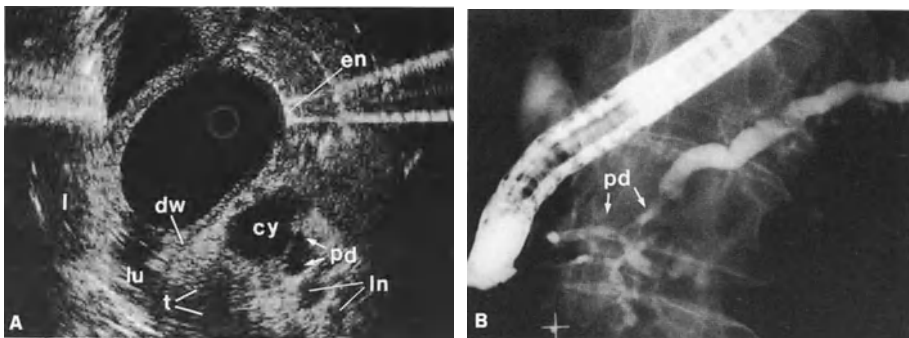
A Endoscopic sonogram showing a hypoechoic tumor (*t*) adjacent to a cystic lesion (*cy*) and the pancreatic duct (*pd*), with a biliary endoprosthesis (*en*). *lu*, lumen; *ln*, lymph node; *l*, liver. B Endoscopic retrograde cholangiopancreatogram revealing circumscribed narrowing of the pancreatic duct (*pd*) in the periampullary region
